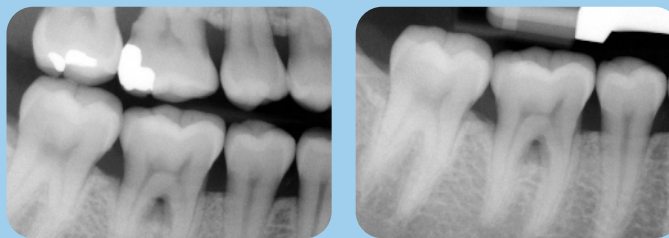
Radiographic presentation of tooth #30.
